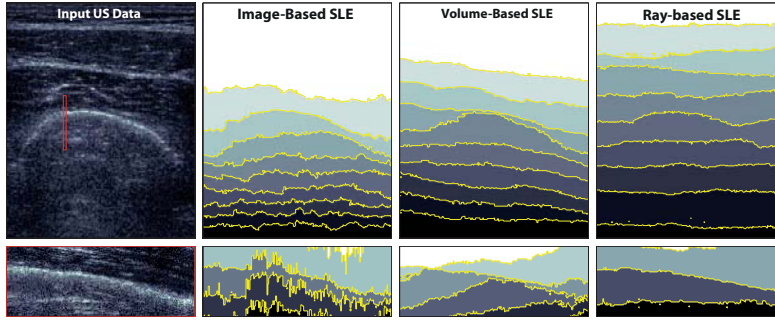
Loss Estimates for Bone Ultrasound As for the carotid datasets (cf. Fig. B.1), cross-sectional and longitudinal slices for the compared methods (second and third column) exhibit a strong variation for image and volume bases estimates, while our ray-based method provides consistent estimates, properly modeling the bone structure also in elevational direction.
